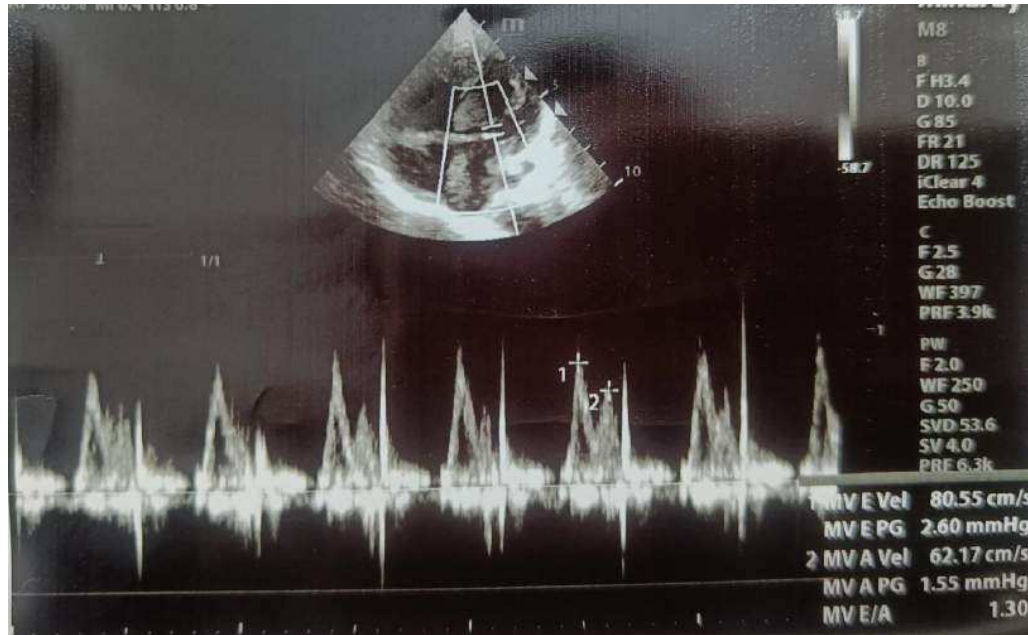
Echocardiography showing E/A ratio of 1.3 suggestive of normal left ventricle diastolic function.
